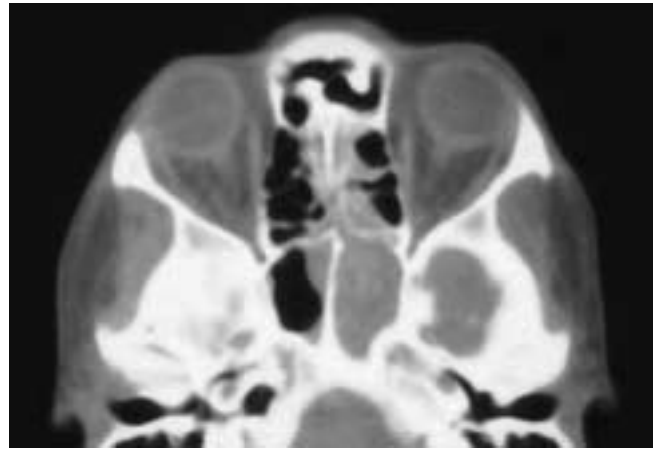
Axial CT scan of a patient with left optic neuritis and a chronic suboccipital headache. The brain was normal on CT and MR studies. There is opacification of the left sphenoid sinus, and minimal mucosal disease is present in the right sphenoid sinus and in both ethmoid sinuses. The patient had no symptoms referable to the sinuses. Surgery revealed sinusitis, and in the immediately postoperative period the patient's headache and visual findings resolved. The walls of the sphenoid sinus were intact.
